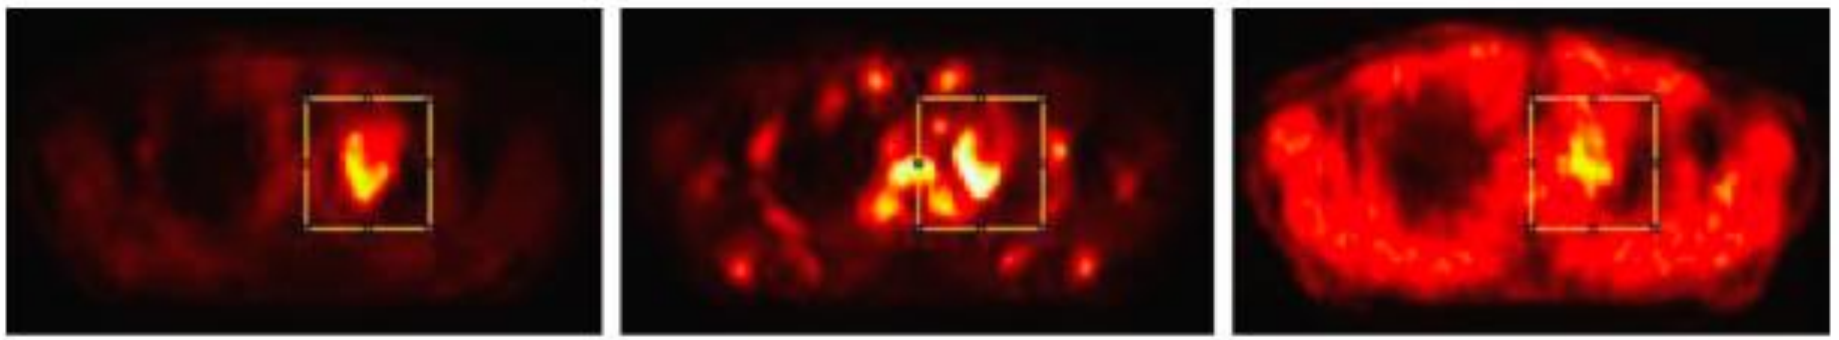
^{18}F -FDG PET/CT for the evaluation of the response to chemotherapy in a patient with Hodgkin Lymphoma, see text. (Courtesy of Paola Erba, University of Pisa, 2014). [A.Del Guerra et al., *Rivista Nuovo Cimento* [2016, Vol. 39(4), pp.155-223]
